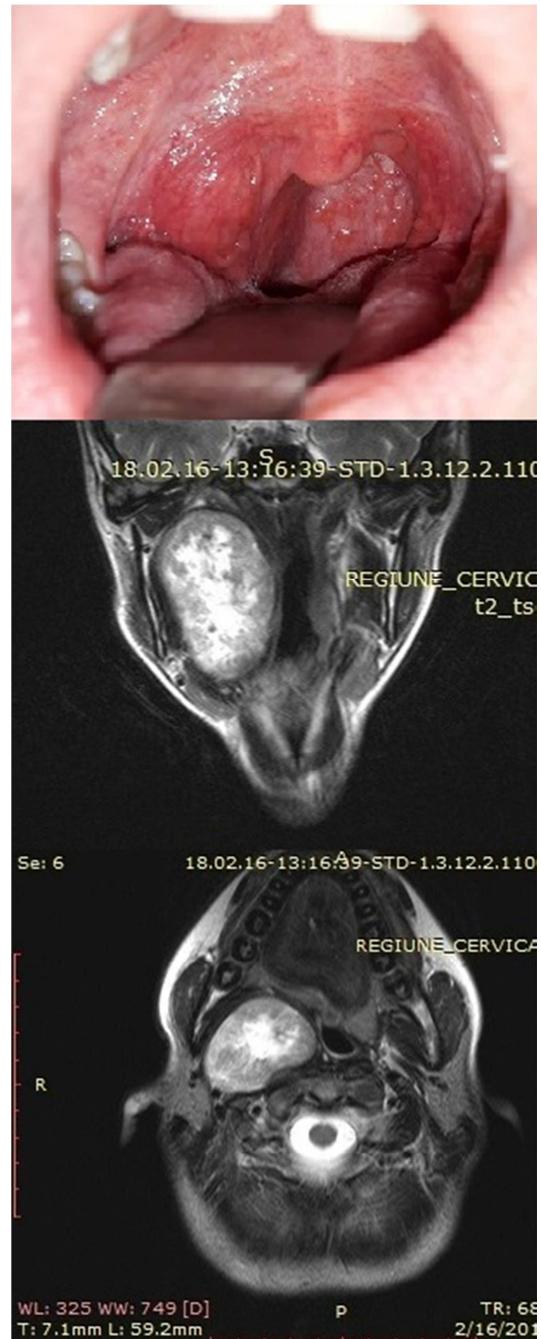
Clinical and imagistic (MRI) aspects of parapharyngeal space tumour (prestyloid compartment).
